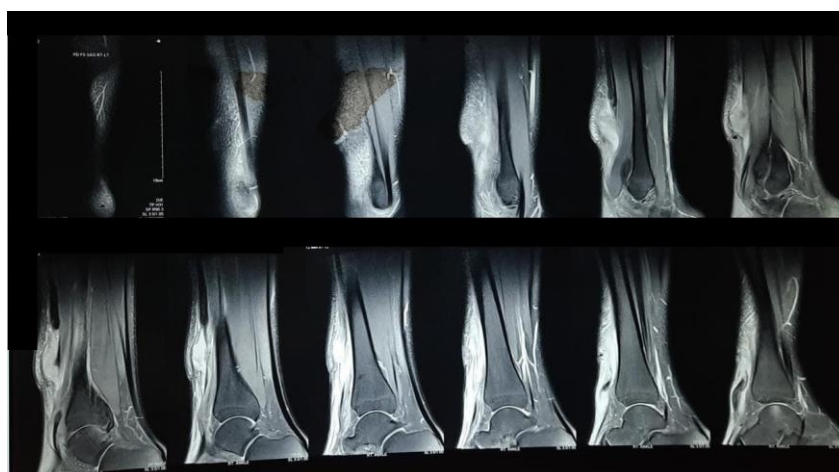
MRI Showing discontinuity in tendon
